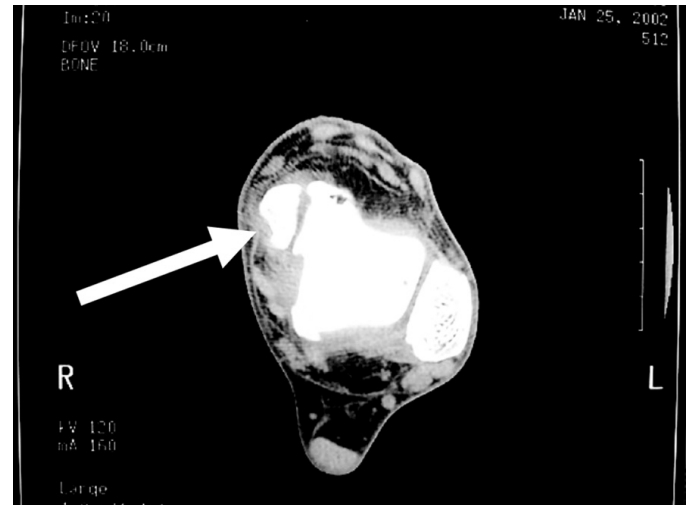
Axial CT image of the left ankle 7 years post injury showing an irregular ossific density medial to the medial malleolus. The white arrow indicates the area of ossification.
